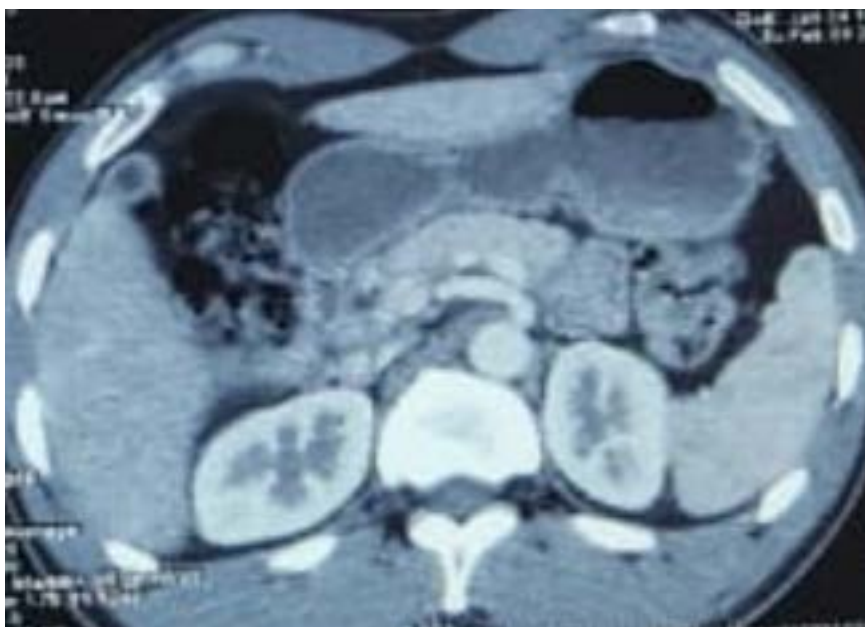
Abdominal CT scan showing diffuse pancreatic hypertrophy with a peripheral hypodense rim.
